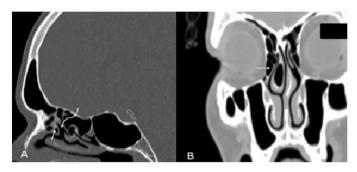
A: Computed tomography of the paranasal sinus (Sagittal section) shows agger nasi cell (red arrow), supra agger cell (blue arrow), supra bullar cell (curved arrow), and supra bullar cell (curved arrow), and supra bullar frontal cell (asterisk). 2B - Coronal non-contrast CT scans of the paranasal sinuses show an air cell within the intersinus septum (arrow) – Frontal septal cell.
